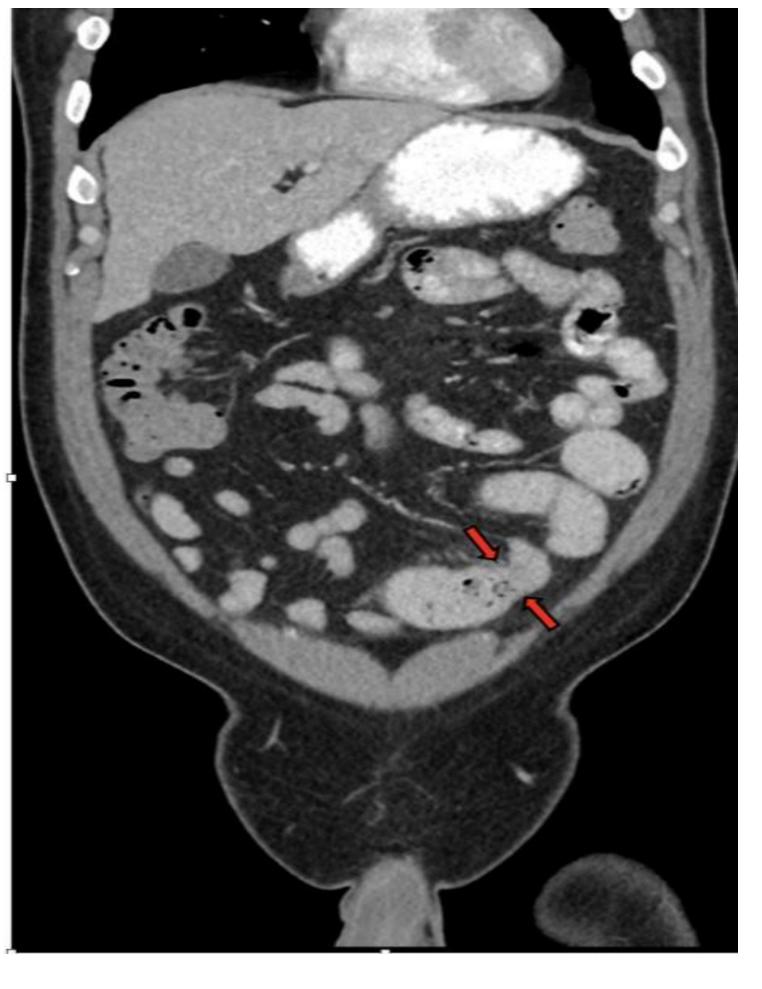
CT with positive oral contrast showing wasting in the small bowel (red arrows).
